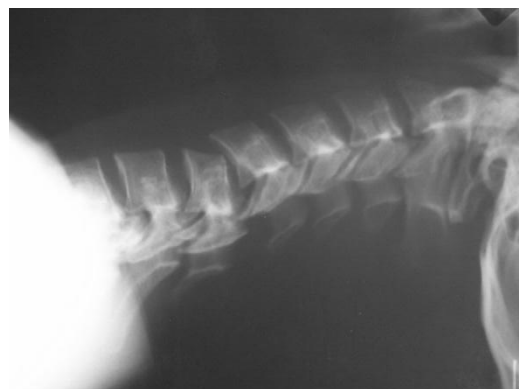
Lateral x-ray of the cervical spine indicating a C5/6 facet dislocation
